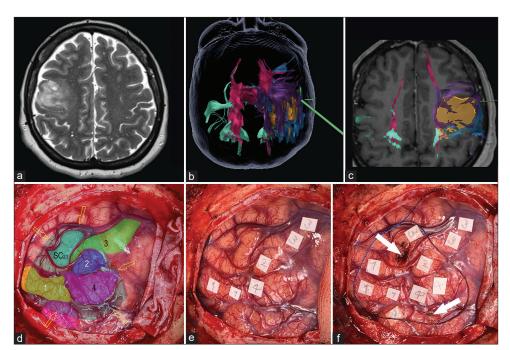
Preoperative magnetic resonance imaging, neuronavigation fused tractography, and intraoperative images of an intentional biopsy. (a) Axial T2 image reveals a right frontal heterogeneous hyperintense intra-axial lesion. (b and c) Neuronavigation images of tractography of descending motor pathways. The volumetric reconstruction of the tumor is shown in yellow. Also shown are the motor tracts coming from the posterior limb of the internal capsule (pink), from the supplementary area (purple), and from the medial (green) and lateral (blue) precentral gyrus. (d-f) Intraoperative images of brain mapping with direct cortical stimulation. Numbers 1 (yellow), 2 (dark blue), 3 (green), and 4 (pink) show the motor areas of the tongue, eye, upper limb, and mouth, respectively. Yellow arrows show the borders of the tumor area verified with the neuronavigation system; white arrows show the safest areas of the cortex from which the biopsy was taken. The aquamarine area (SC2,3) shows where a subcortical response from the eye and the upper limb was noted during subcortical mapping during the biopsy.
